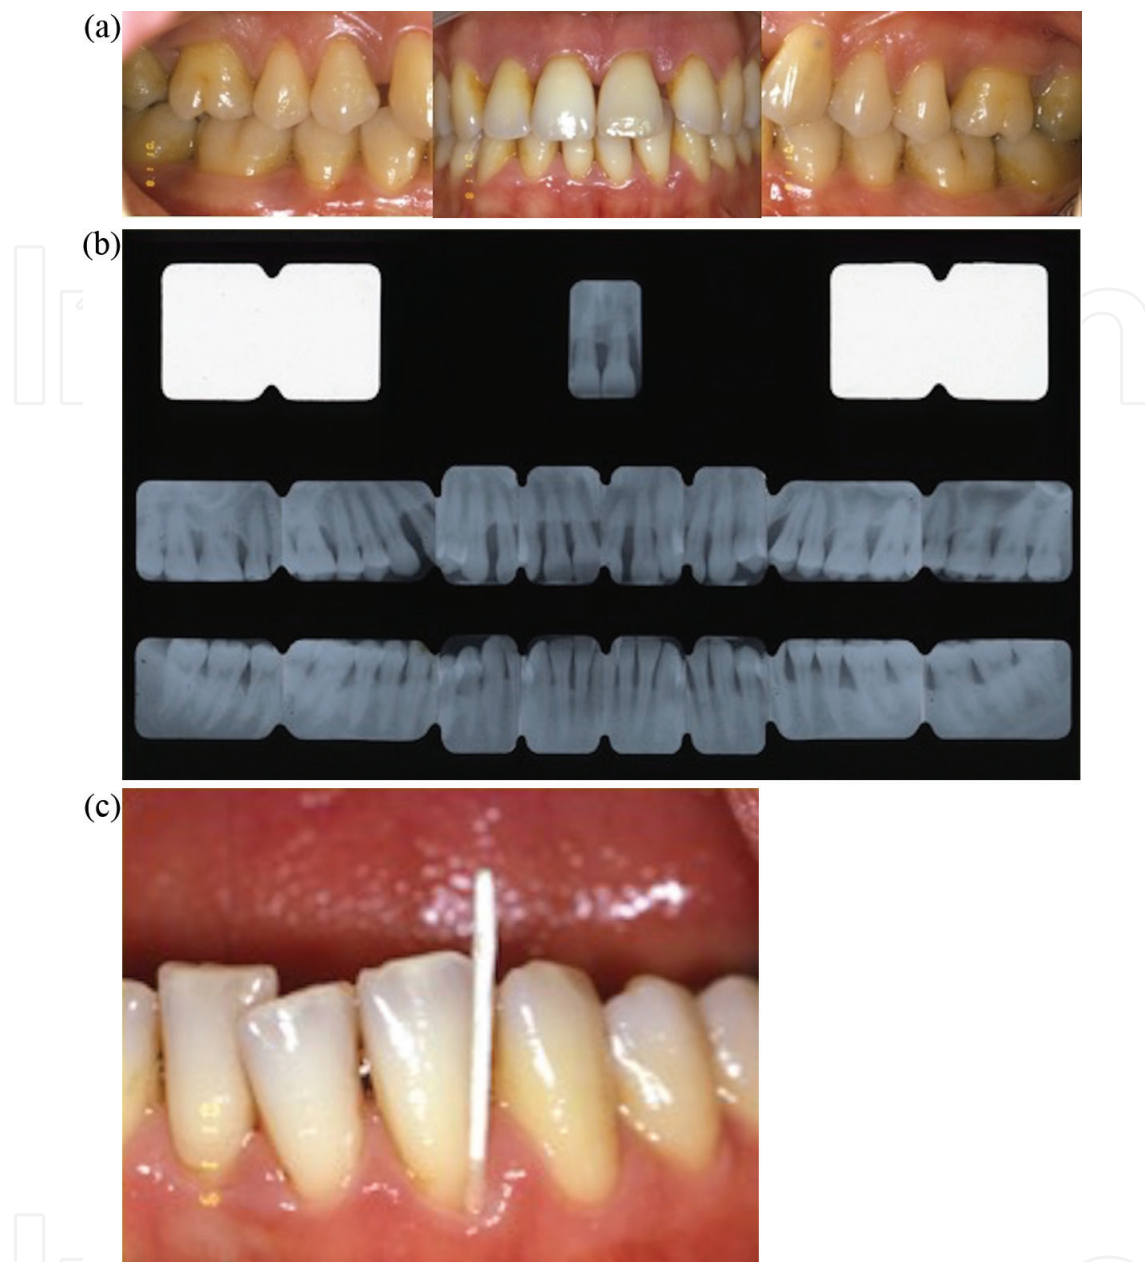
Twenty-eight-year-old female patient (FG), whose major requirement is diastema closure and teeth alignment. (a) Intraoral aspect; (b) during periodontal probing, it is noticed the presence of infrabony defects in multiple sites on both maxilla and mandible. A complete series of periapical radiographs is performed, showing a diffuse bone loss. (c) Bacteriological analysis on collected gingival cervical fluid indicated high levels of *actinobacillus actinomycetemcomitans*, *porphyromonas gingivalis* and *prevotella intermedia*.
